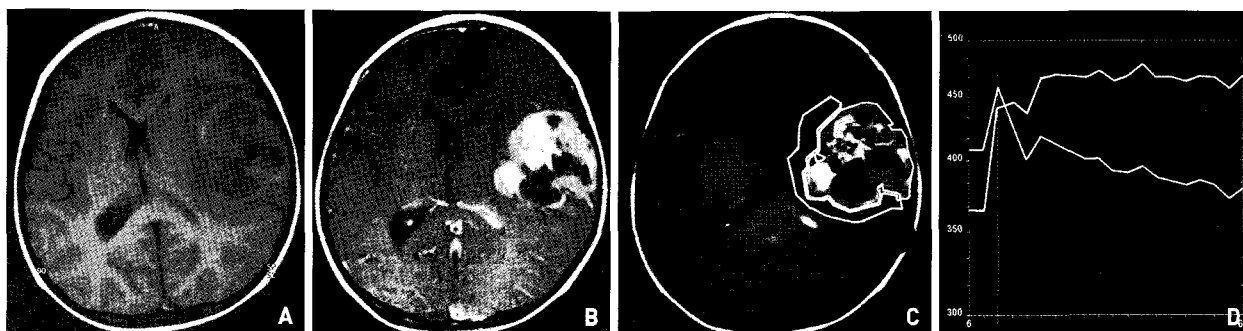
Magnetic resonance images of the brain and dynamic scans were taken on the enhancing and surrounding areas in 3-year-old male patient with intraparenchymal ependymoma (case 14). A : T1-weighted axial image. B : Enhancement with Gd-DTPA. C : Region of interest on the enhancing (yellow) and surrounding (white) areas. D : Dynamic scan on the enhancing area shows "T pattern" (yellow curve) and that on the surrounding area shows "N pattern" (white curve).
